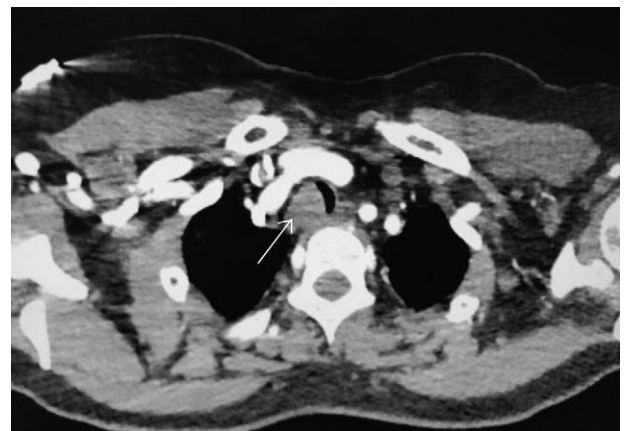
Contrast axial CT image shows an enhancing soft tissue density mass arising from the right posterolateral wall of the trachea. The arrow shows the tumor in the trachea.
